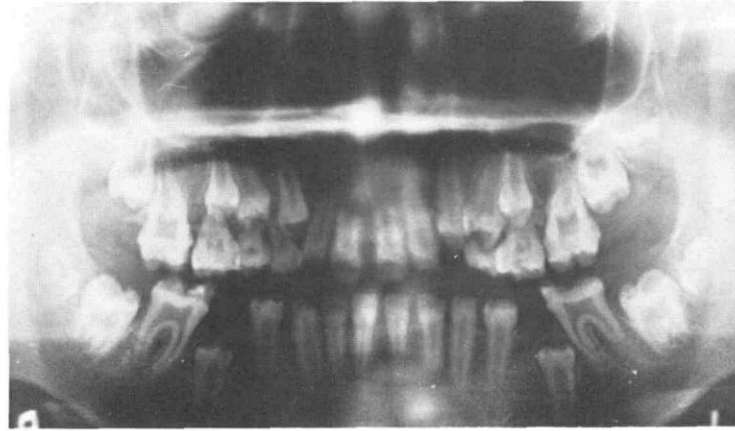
Radiographic evidence of enamel hypoplasia-Panoripse.
